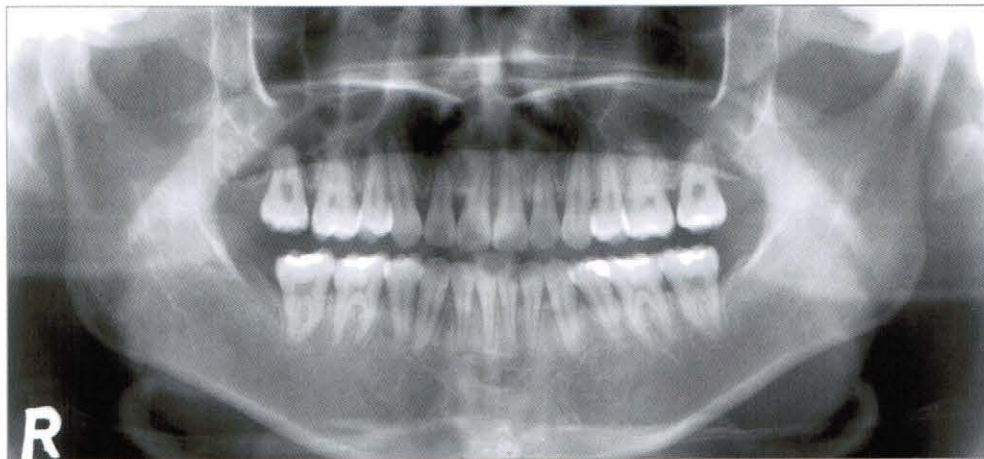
Panoramic radiograph at debonding. The upper lateral incisor root axis has been corrected.
